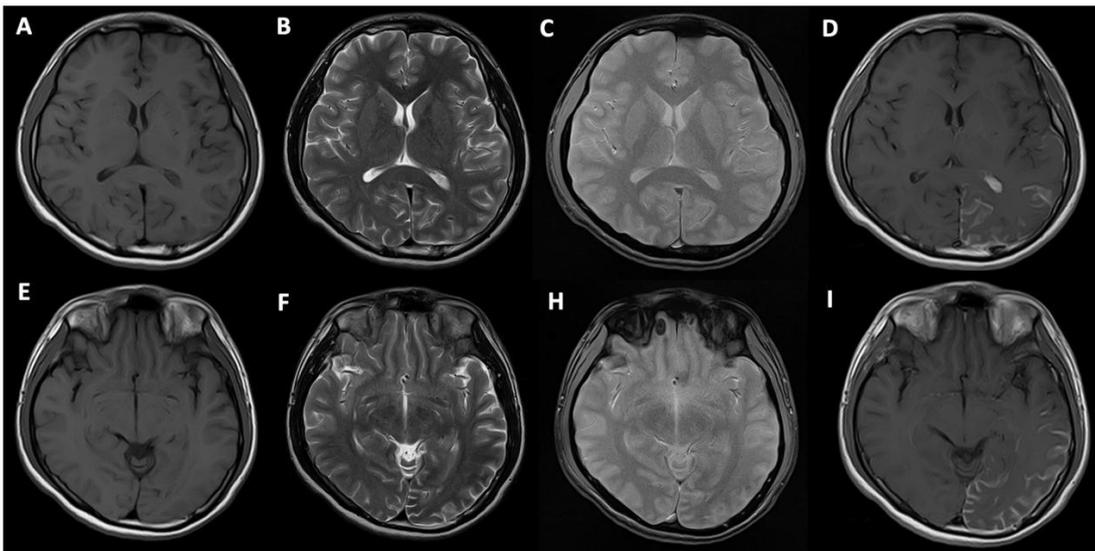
MRI Brain at the level of (A-D) lateral ventricles and (E-I) midbrain in T1-weighted (A, E), T2-weighted (B, F), gradient echo (C, H) and T1-weighted post-contrast sequences showing left parietal pial angiomatosis with no abnormal signals on T1-weighted, T2-weighted and gradient-echo (GRE) sequences corresponding to the tram-track calcifications seen on initial CT.
